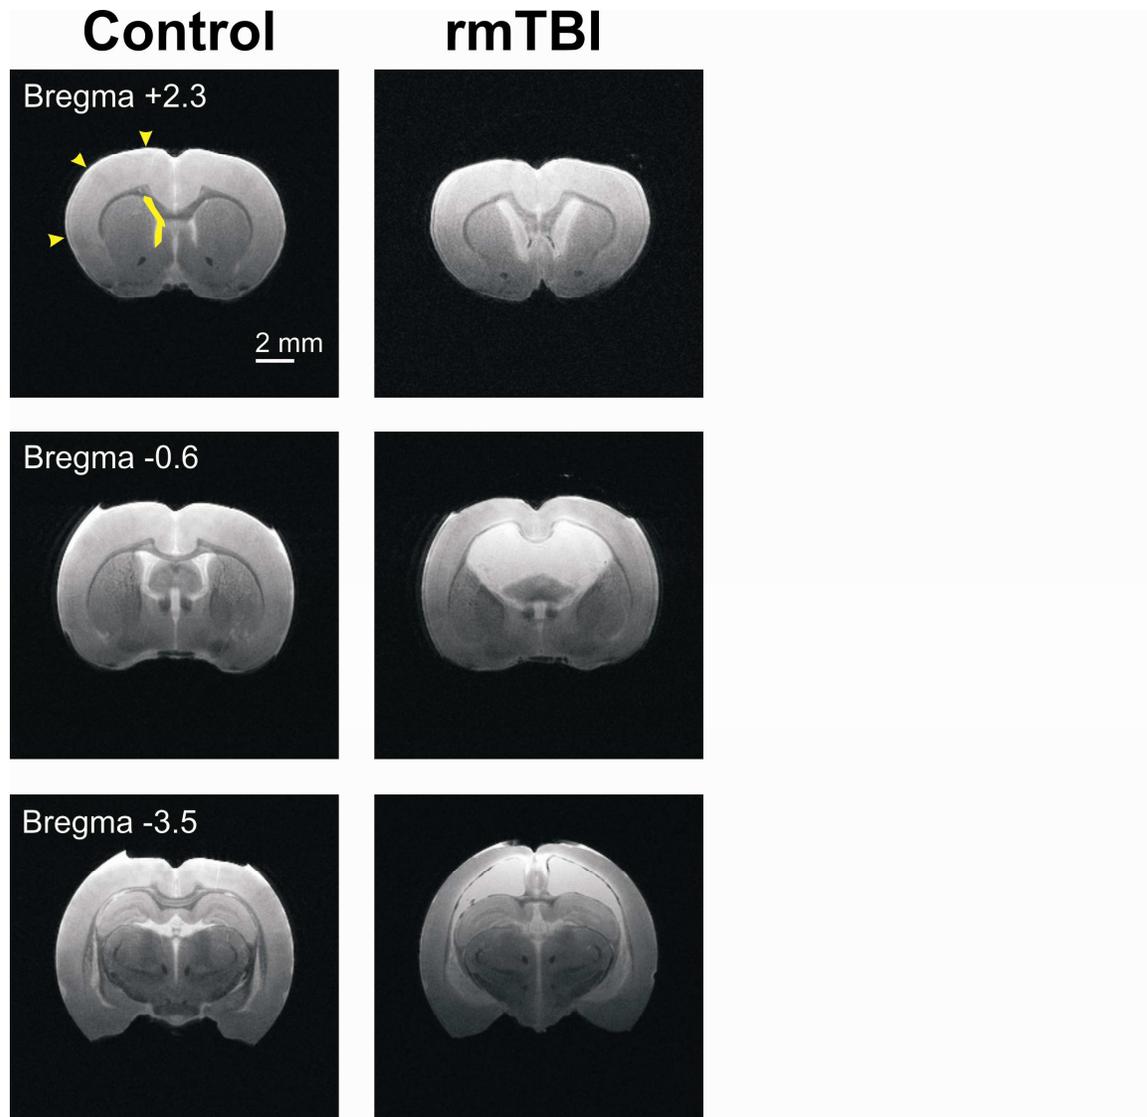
Magnetic Resonance Imaging (MRI) reveals significant structural changes following rmTBI. Coronal T2 weighted MRI images were obtained with a 7T MRI scanner from perfusion fixed brains 14 days after sham or rmTBI. Representative images from sham (left) or rmTBI (right) are presented. Approximate anatomical position of images are referenced relative to bregma. Scale bar represents 2mm. Yellow arrowheads and box represent regions where cortical depth and lateral ventricle area measurements were taken. Similar respective measurements were made across all sham and rmTBI images. In T2 weighted images water and edema are bright while gray and white matter appear darker. Note the significant cortical thinning and ventriculomegaly evident in rmTBI brains.
